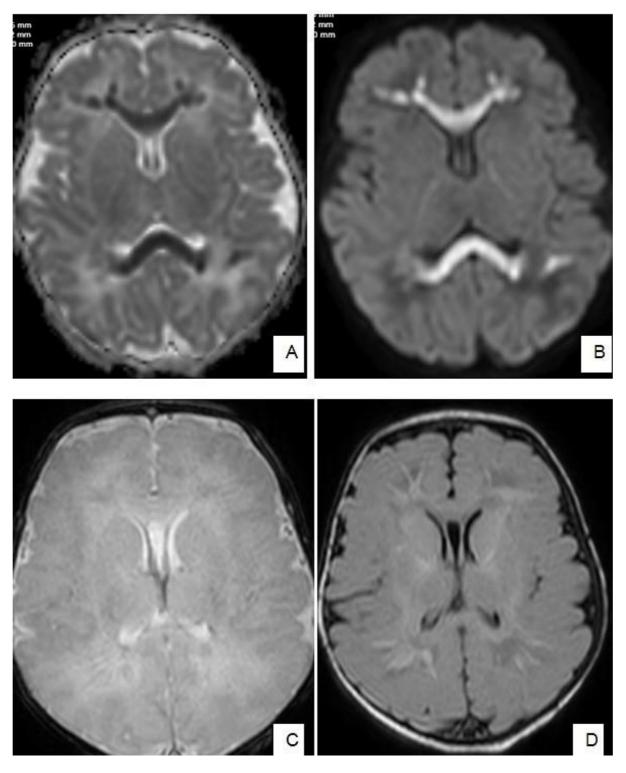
An eight day old male neonate presented with decreased responsiveness and had to be intubated because of low oxygen saturation in the ICU, MR imaging of the brain revealed altered signal intensities in bilateral corona radiata, genu and splenium of corpus callosum, subcortical white matter of bilateral fronto-temporo-parietal lobes with true restricted diffusion depicted in Figs [A] and [B] and appeared hyperintense on T2/ FLAIR depicted in Fig: [C] and [D].
